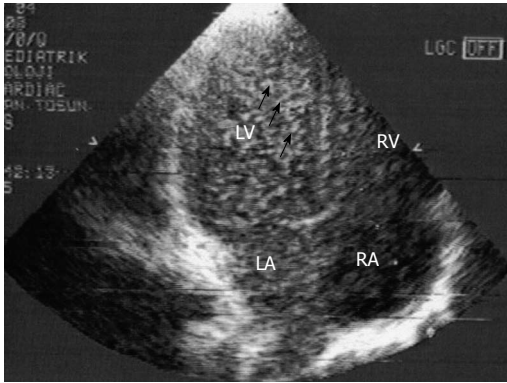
“Bubble” or contrast echocardiogram (apical four chamber view). A stream of microbubbles filling the left atrium following systemic venous injection is shown.
